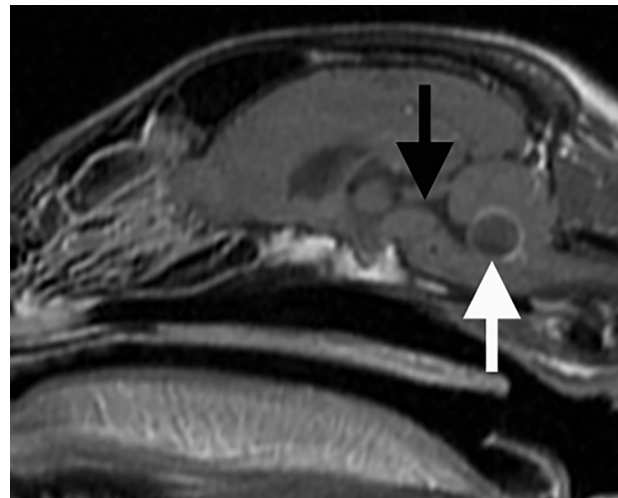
Sagittal plane T1-weighted image (obtained after contrast agent administration) of the brain of a 4-year-old Shetland Sheepdog that had sudden-onset ataxia of 12 hours' duration. Notice the round lesion in the fourth ventricle with mild rim enhancement (white arrow) and mild dilation of the ventricular system rostral to the lesion (black arrow).
